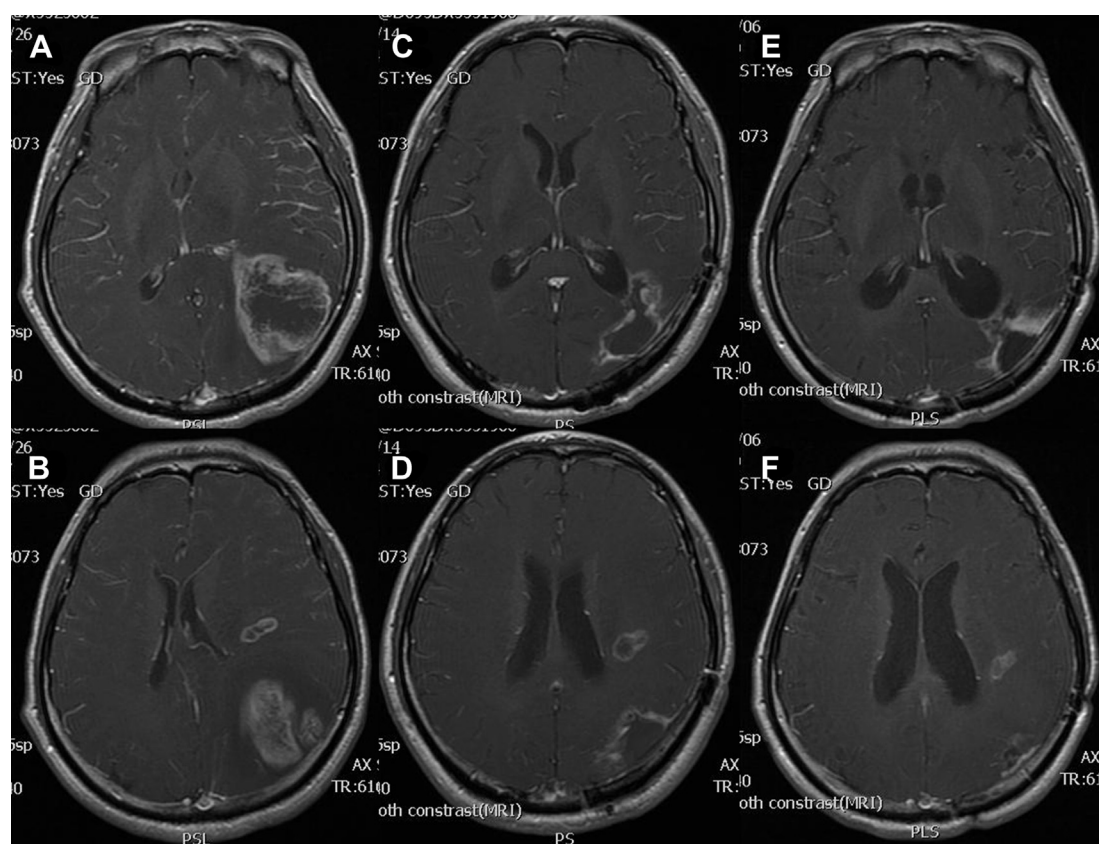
Gadolinium-enhanced axial T1-weighted MRI showing the intracranial tumors prior to surgery (A, B), after CCRT and 5-month adjuvant chemotherapy (C, D), and after spinal seeding had been diagnosed (E, F).
